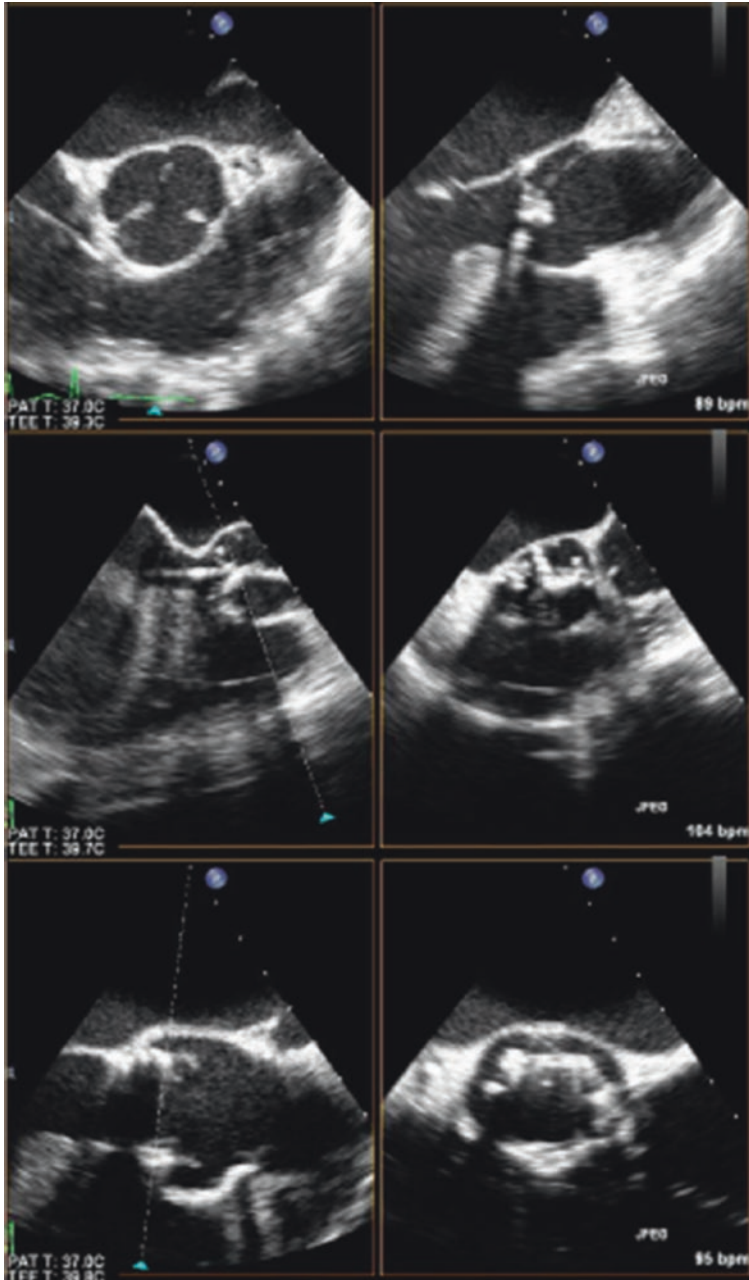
Biplane real-time three-dimensional (3D) echocardiography. Biplane real-time imaging of a patient with severe aortic stenosis undergoing transcatheter aortic valve implantation (TAVI), in both short and long axis, before (*top panel*), during (*middle panel*), and after (*bottom panel*) device deployment. Simultaneous imaging of the aortic valve in two planes in high spatial and temporal resolution is crucial for the precise positioning of the prosthetic device in TAVI
